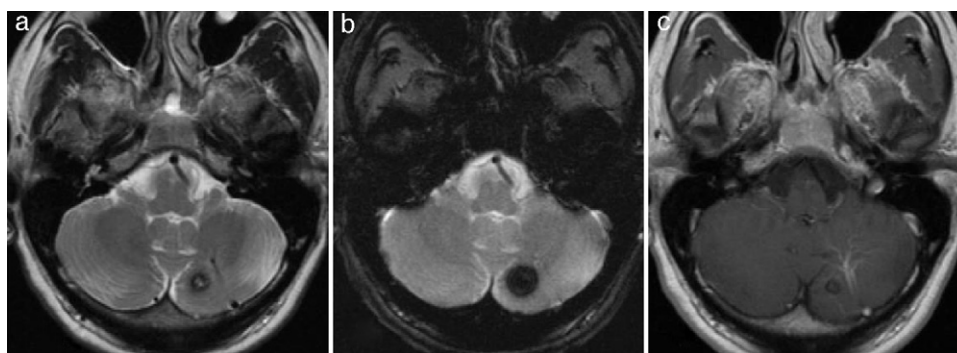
Cavernoma in the left cerebellar hemisphere with associated developmental venous anomaly whose collecting vein drains into the left transverse sinus. (a) and b) T2-weighted cranial MR image and T2 gradient-echo cranial MR image in the axial plane. Cavernoma in the left cerebellar hemisphere. An associated developmental venous anomaly can be guessed in (a). (c) Axial T1-weighted sequence clearly shows enhancement of the developmental venous anomaly and absence of enhancement of the cavernoma after administration of intravenous gadolinium.
